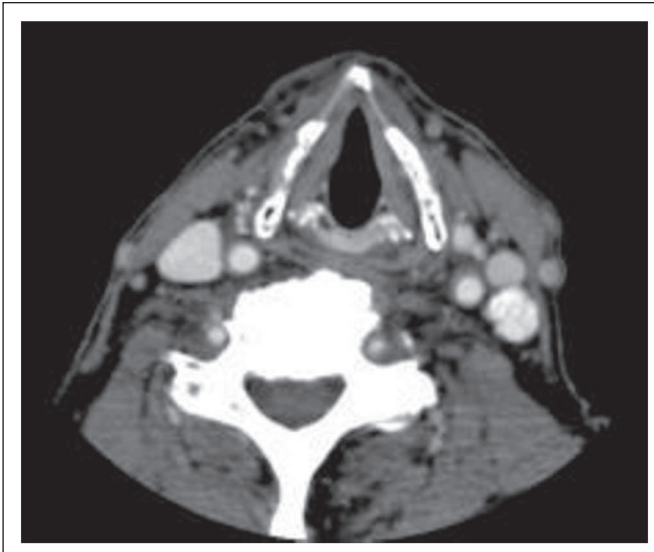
This 83-year-old patient received radiotherapy (76.8 Gy at 1.2 Gy/fraction bid) for T2N2b base of tongue cancer. Postradiotherapy computed tomography demonstrated a 1.1-cm lymph node with definite calcification in the left neck at level III. Neck dissection was positive, with extracapsular extension. The patient died of intercurrent disease with 4 months of follow-up.
